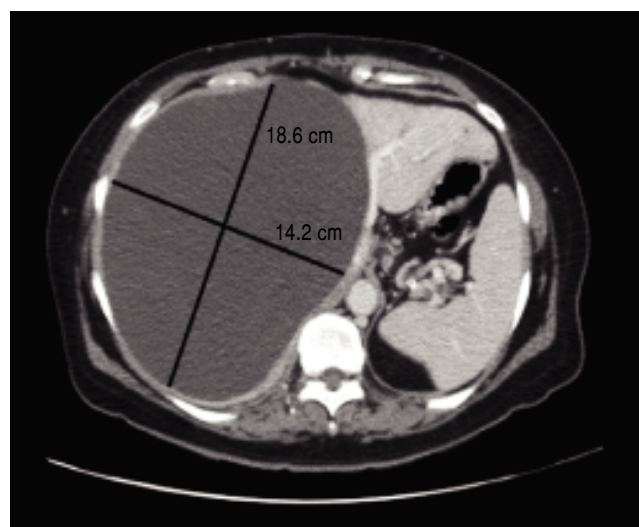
CT Abdomen on presentation showing huge liver cyst.
